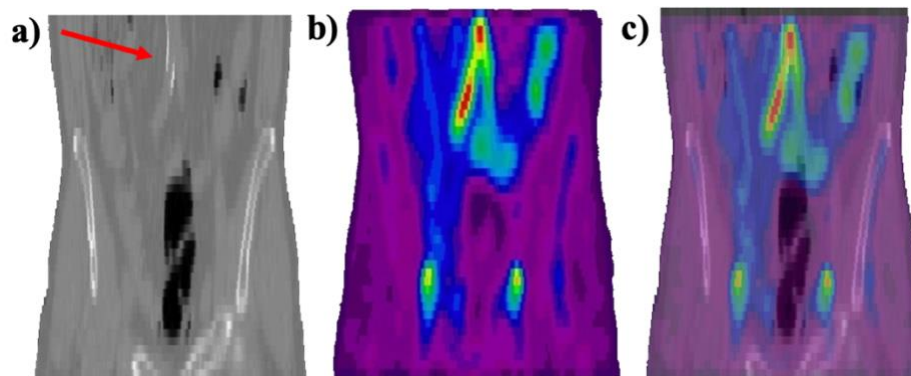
PET/CT coronal images of the abdomen, a) CT with calcification (arrow), b) PET image and c) fused PET-CT.
